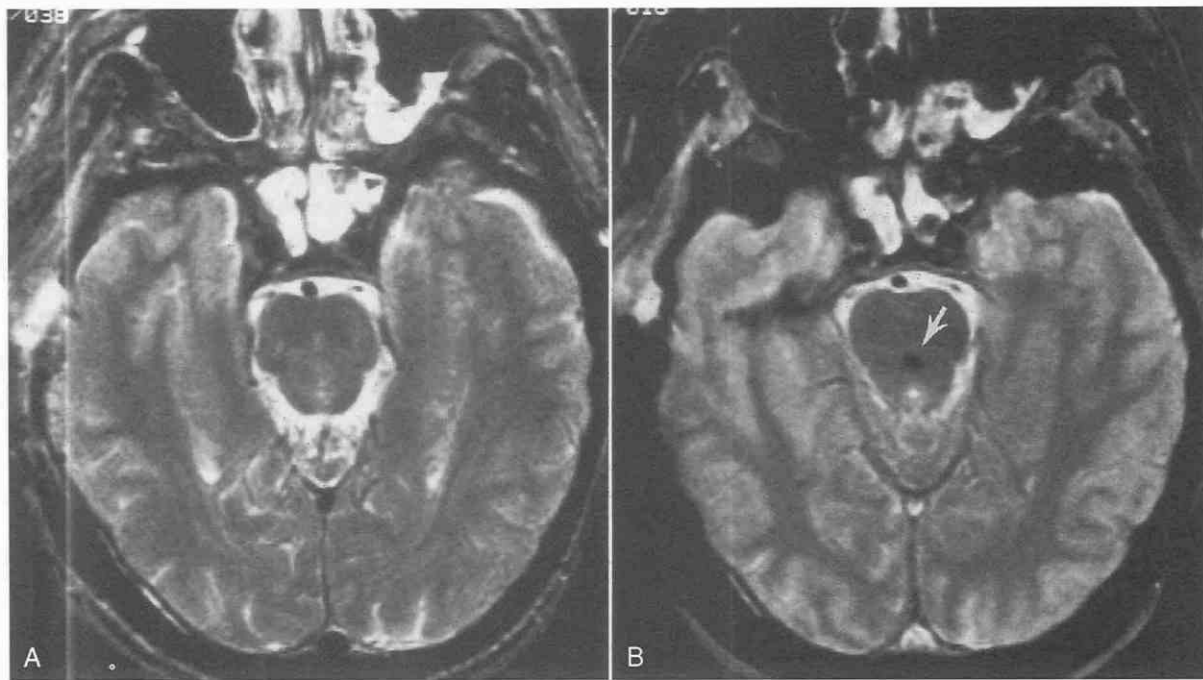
A, Axial T2-weighted (2600/80) MR image shows no abnormality in a comatose patient. B, Axial T2* gradient-recalled echo (600/17), 20-degree flip-angle image reveals a small acute hemorrhagic contusion in the pons (arrow).
